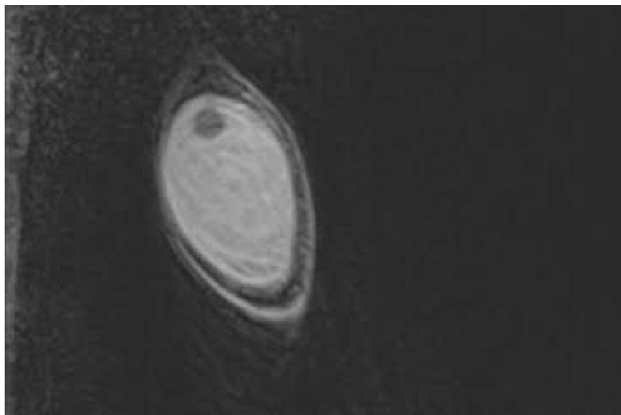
MRI of the cyst
